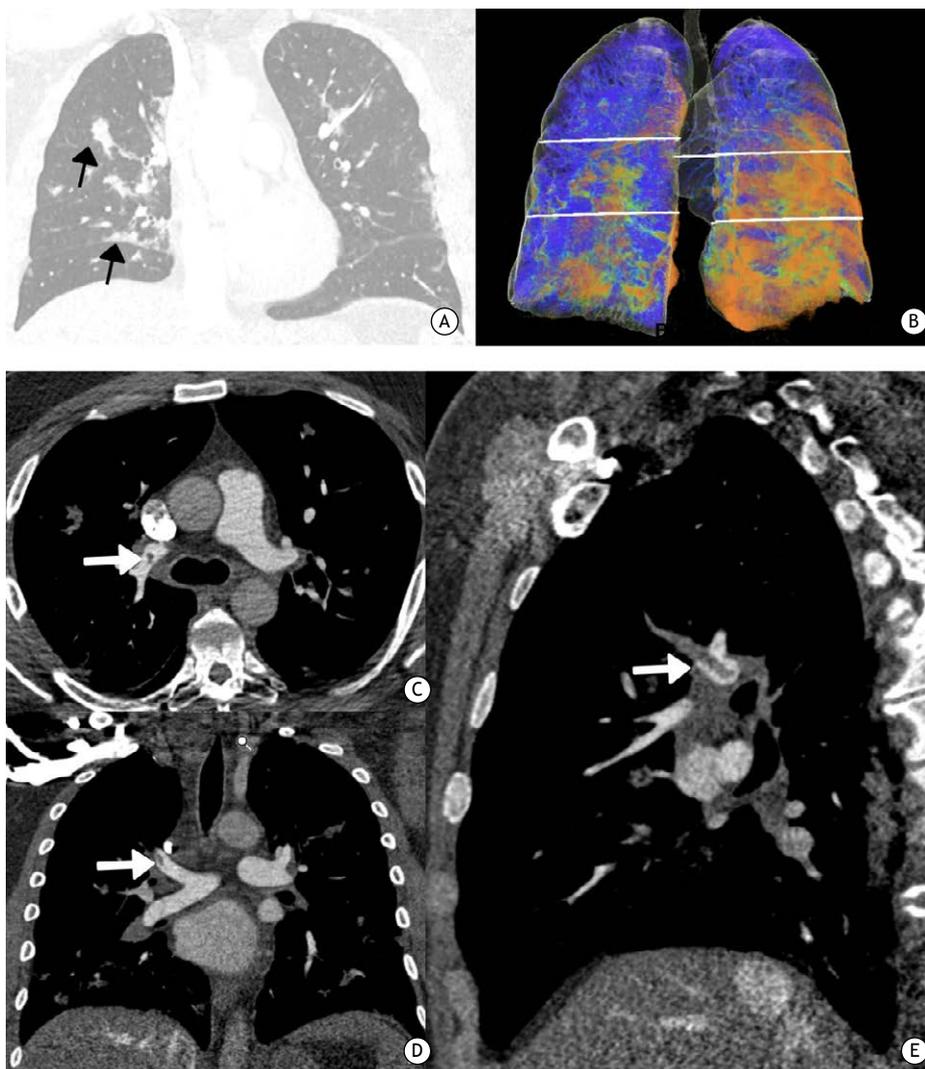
A CT scan of the chest showing foci of consolidation (in A) one week after an initial scan had shown only opacities and ground-glass attenuation, consistent with the usual evolution of COVID-19 pneumonia. A posterior projection of the lungs using three-dimensional reconstruction (in B) shows the extent of lung parenchyma involvement (37.7%), predominantly in the posterior region. CT angiography of the chest showing a central filling defect—white arrows in C (axial reconstruction), D (coronal reconstruction), and E (sagittal reconstruction)—in the branch of the right pulmonary artery to the upper lobe, consistent with acute pulmonary thromboembolism.
